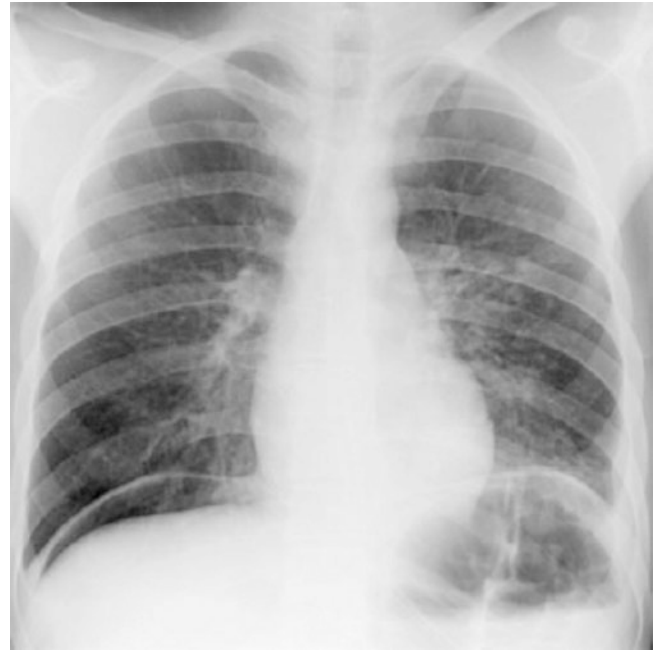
Upright chest radiograph with pneumoperitoneum noted under the right hemidiaphragm
